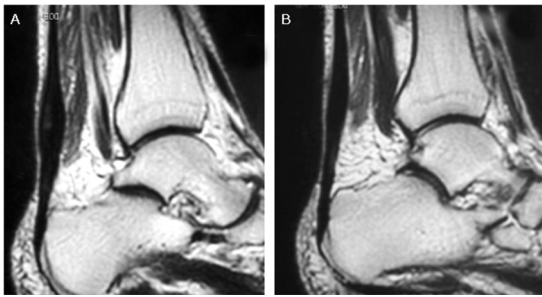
MRI of a CRAT case successfully treated with leukocyte-rich PRP. (A) MRI at baseline; (B) MRI at 55 months of follow-up.
